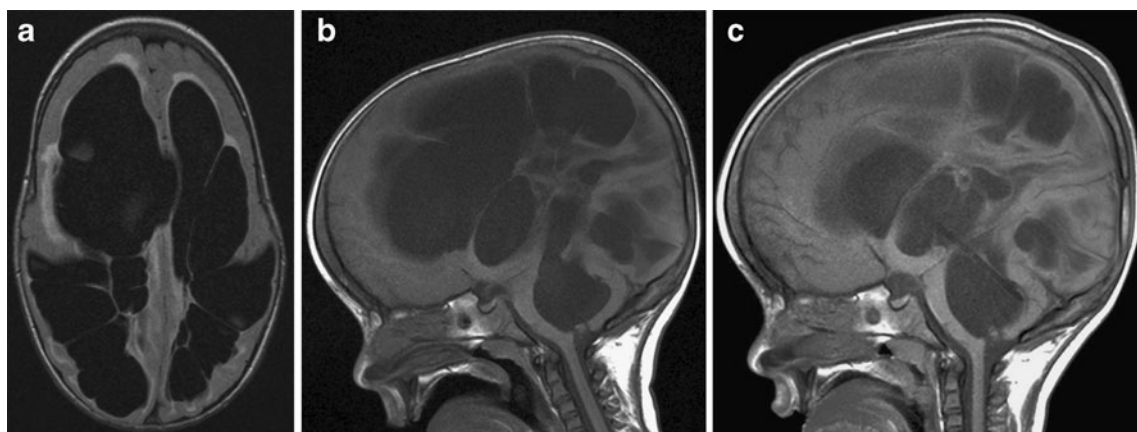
a–c Pre- and post-operative magnetic resonance images of case 2, demonstrating complex ventricular anatomy and correct placement of the fourth ventricle shunt catheter. a Pre-operative axial T1-weighted MRI, b
